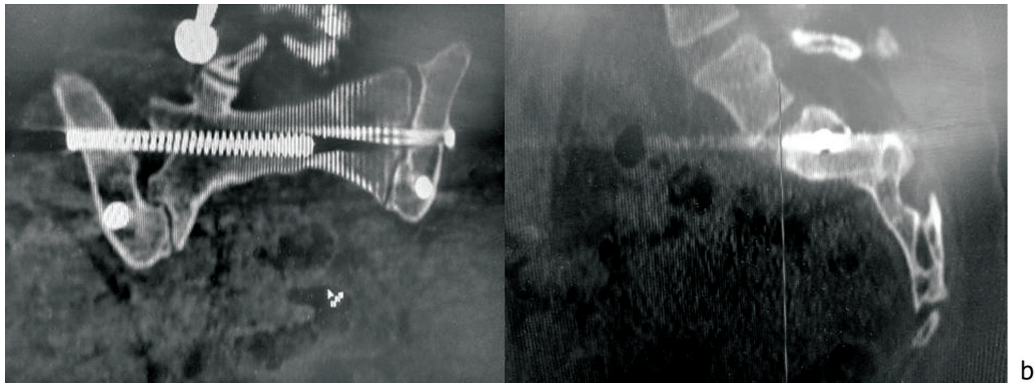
(continuation) Computed tomography scans of the pelvis at 12 months of surgery (b) scans in frontal and sagittal planes
